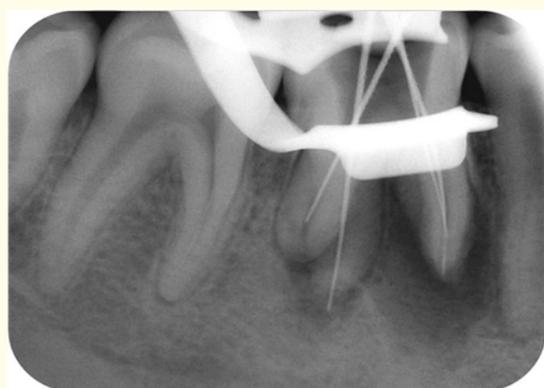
Working length IOPA radiograph of tooth #46 with mesial angulation.
